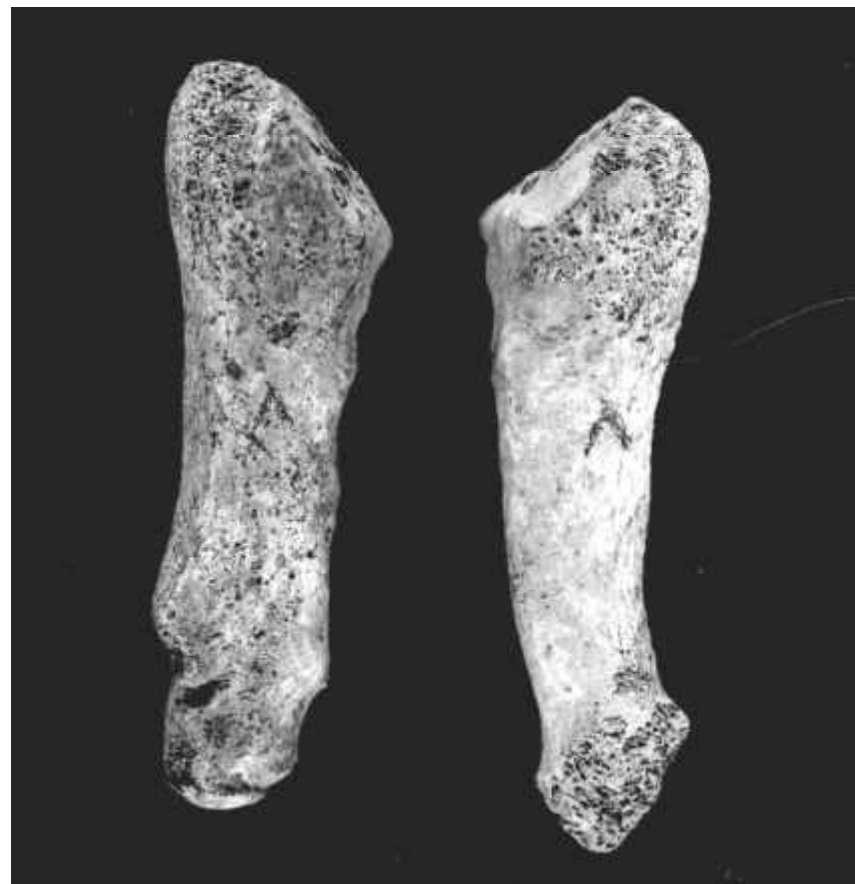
Context 615: The 5th left metatarsal (left of photo) has been fractured (also Xrayed). Compare with normal 5th right metatarsal (right of photo)
